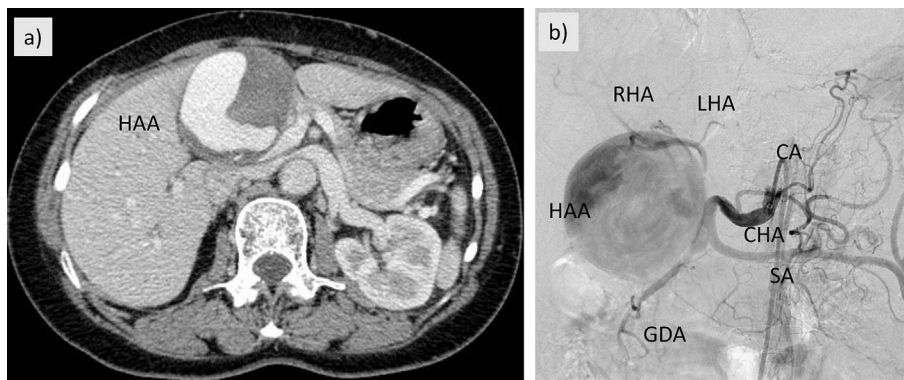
(a) Contrast enhanced computed tomography revealed a huge aneurysm of the common hepatic artery. (b) Coeliac angiography demonstrated a saccular aneurysm 11 mm distal to the origin of the proper hepatic artery and 7 mm proximal to the junction of the left and right hepatic artery. *Note.* CA = coeliac artery; CHA = common hepatic artery; SA = splenic artery; GDA = gastroduodenal artery; LHA = left hepatic artery; RHA = right hepatic artery; HAA = hepatic artery aneurysm.
